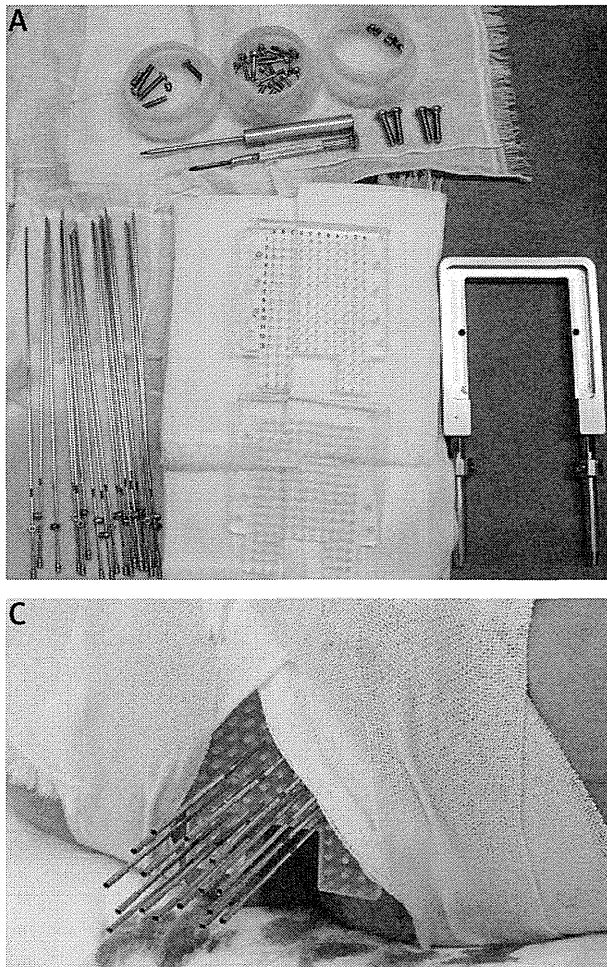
A) Preparation for implant of applicator needles for HDR prostate brachytherapy. An in-house “see-through” template and its cover plate (center), an in-house metallic frame to hold and connect the template with an ultrasonography-probe stepper (right), applicator needles with stoppers (left), and their screws and screw drivers (upper). B) Needle implant under real-time transrectal-ultrasonography guidance. The patient is awake, under epidural anesthesia, in lithotomy position. Template holes had been superimposed on the ultrasonography monitor. C) Fixation of the template with elastic tape. Before taping, the template had been sutured to the perineal skin. Needle stoppers are sandwiched by the template and its cover plate, preventing needle displacement
